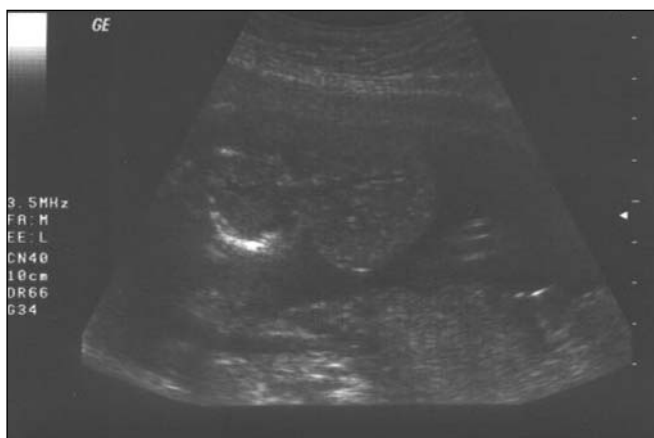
Ultrasound was revealed gastroschisis and extra-abdominal location of fetal liver.
